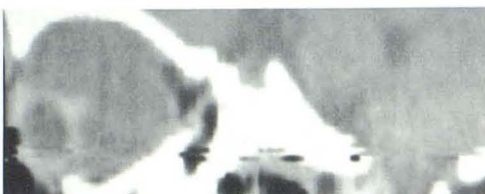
Case 1. Coloboma of optic disk. Axial scan through orbit shows conal appearance of colobomatous right globe. Coloboma directly communicates with vitreous cavity and has same CT attenuation.
